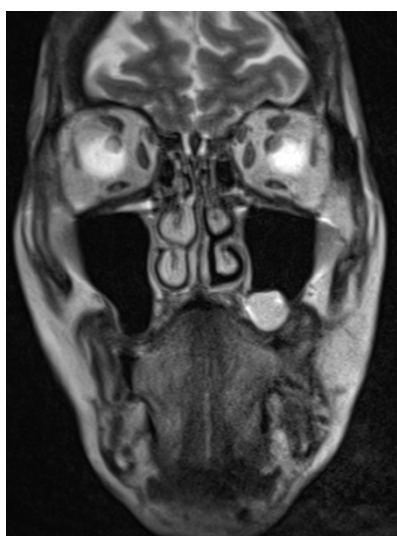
Post-chemotherapy CT coronal section*
